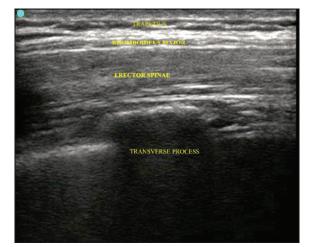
Ultrasound view of erector spinae plane
